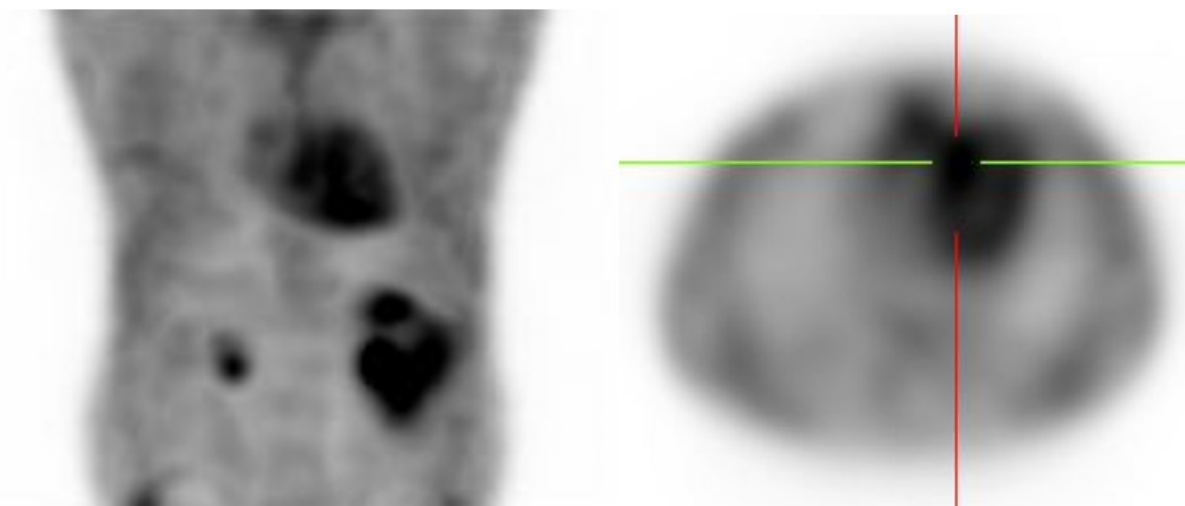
Complementary SPECT imaging of the cardiac PYP scan at 1 hour post-injection (left) with selected axial slice (right) at the level of the myocardium (red and green partial cross). This allowed better localization of tracer activity in the visualized thorax when correlated with the planar images
